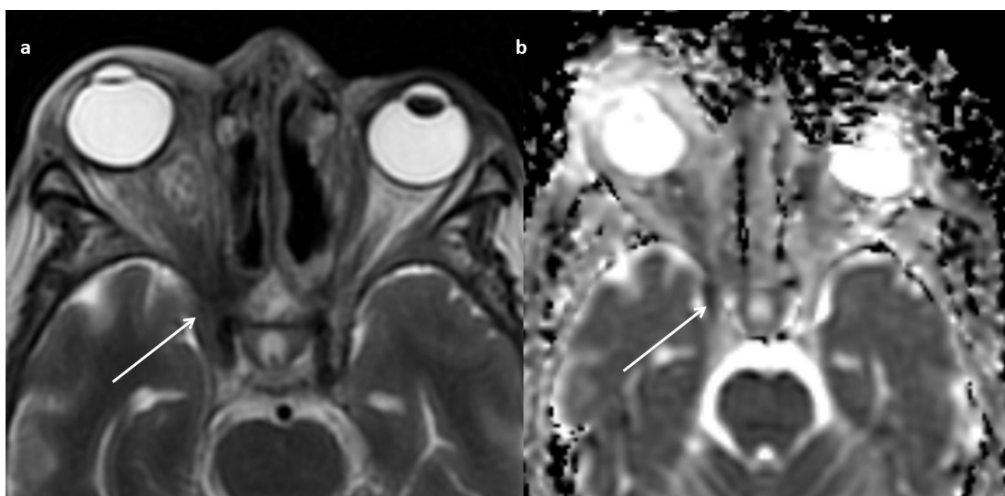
(a) T2-weighted axial MRI showing involvement of intraconal fat and orbital apex on the right side with extension into cavernous sinus (arrow). (b) ADC map of the same patient shows diffusion restriction in the right cavernous sinus (arrow).
